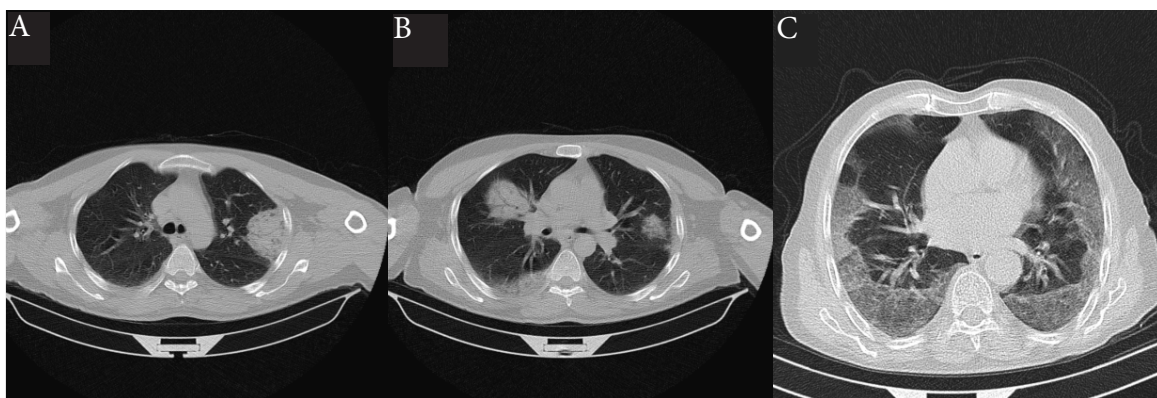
Axial Computerized Tomography of Lungs in 2019-nCoV Infected Cases. A: CT image of patient with fever, cough, and positive RT-PCR test that shows a peripheral consolidation, B: CT image of patient with fever, cough, and positive RT-PCR test that shows multiple subpleural, peribronchovascular consolidation and ground glass opacities and, C: CT image of patient with fever, respiratory distress, and positive RT-PCR test that shows bilateral peripheral ground glass opacities.
